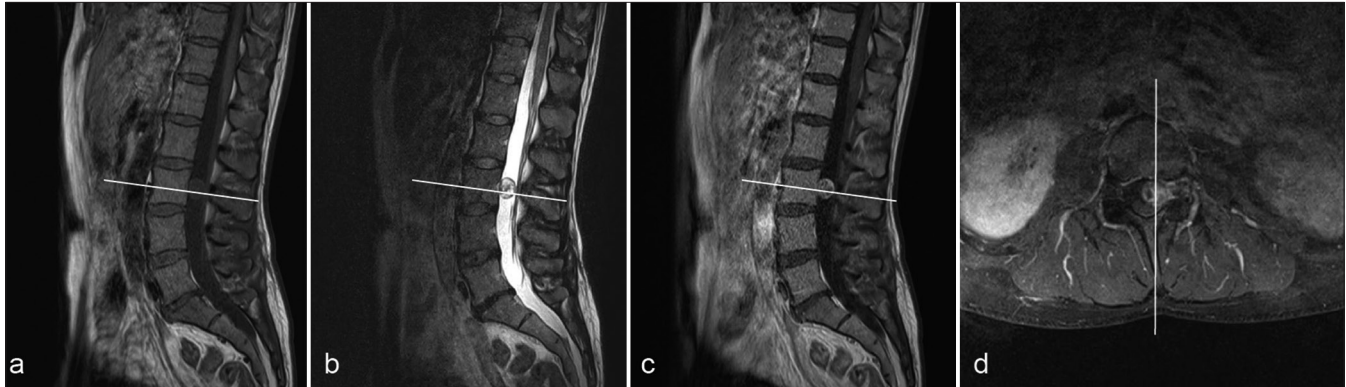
Preoperative magnetic resonance images. (a and b) Sagittal T1-weighted and T2-weighted images show an extramedullary lesion, which is located ventrally in the spinal canal. (c and d) Sagittal and axial contrast-enhanced T1-weighted images show a contrast-enhancing lesion with heterogeneity, which is slightly protruding into the left intervertebral foramen at L3-4. Figures a-c are at the level of the white line in Figure d. Figure d is at the level of the white line in figures a-c.
